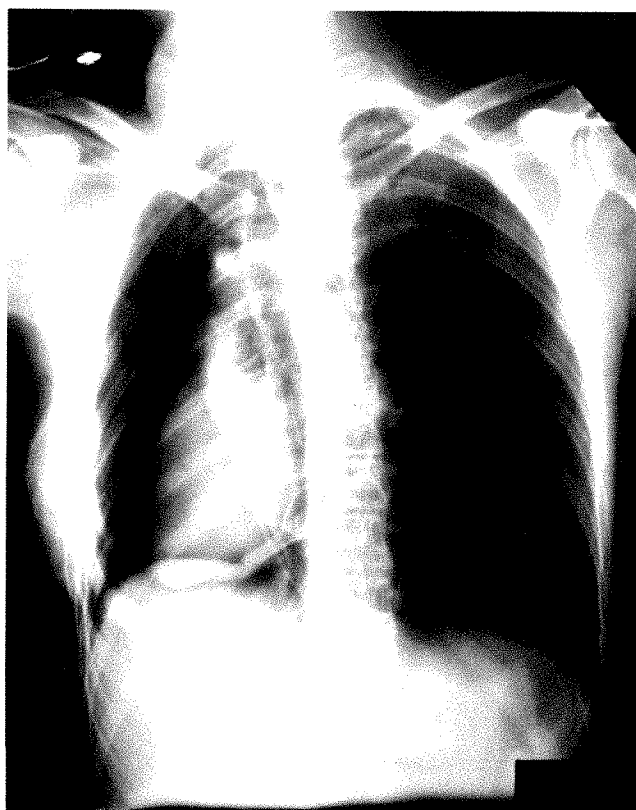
Postoperative chest roentgenogram showing herniation of the heart into the right hemithorax.
